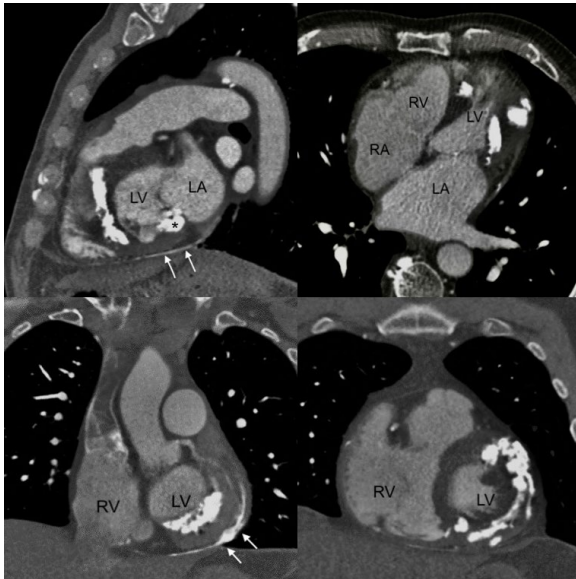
The sagittal (upper left), axial (upper right), and coronal images (lower left and right) of the chest CT demonstrated calcification of LV myocardium, mitral valve annulus (* in upper left image), and pericardium (white arrows in upper and lower left images) over the LV. [LA = left atrium; LV = left ventricle; RA = right atrium; LV = left ventricle.]
